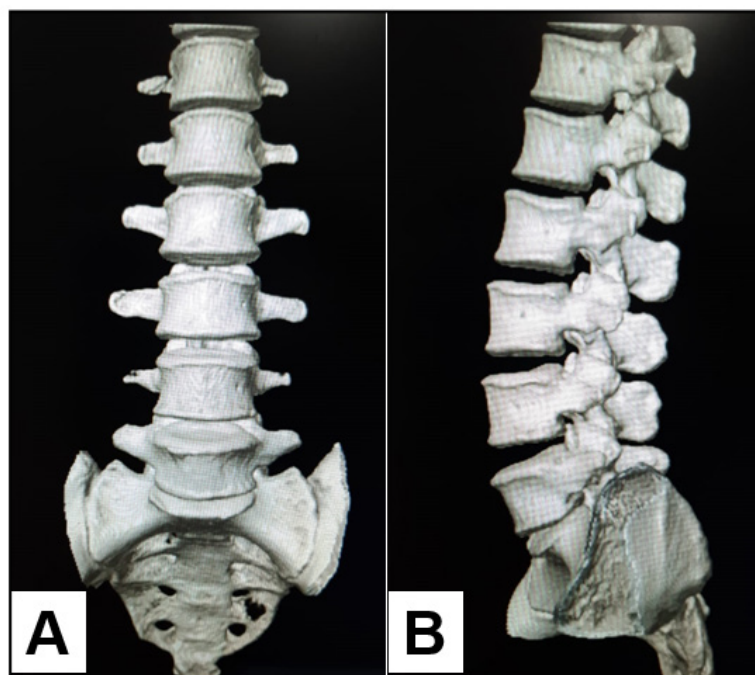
3D reconstruction of CT scan showing 6th lumbar vertebra (A and B) and a clear reduction of the L6–S1 interspace (B).
